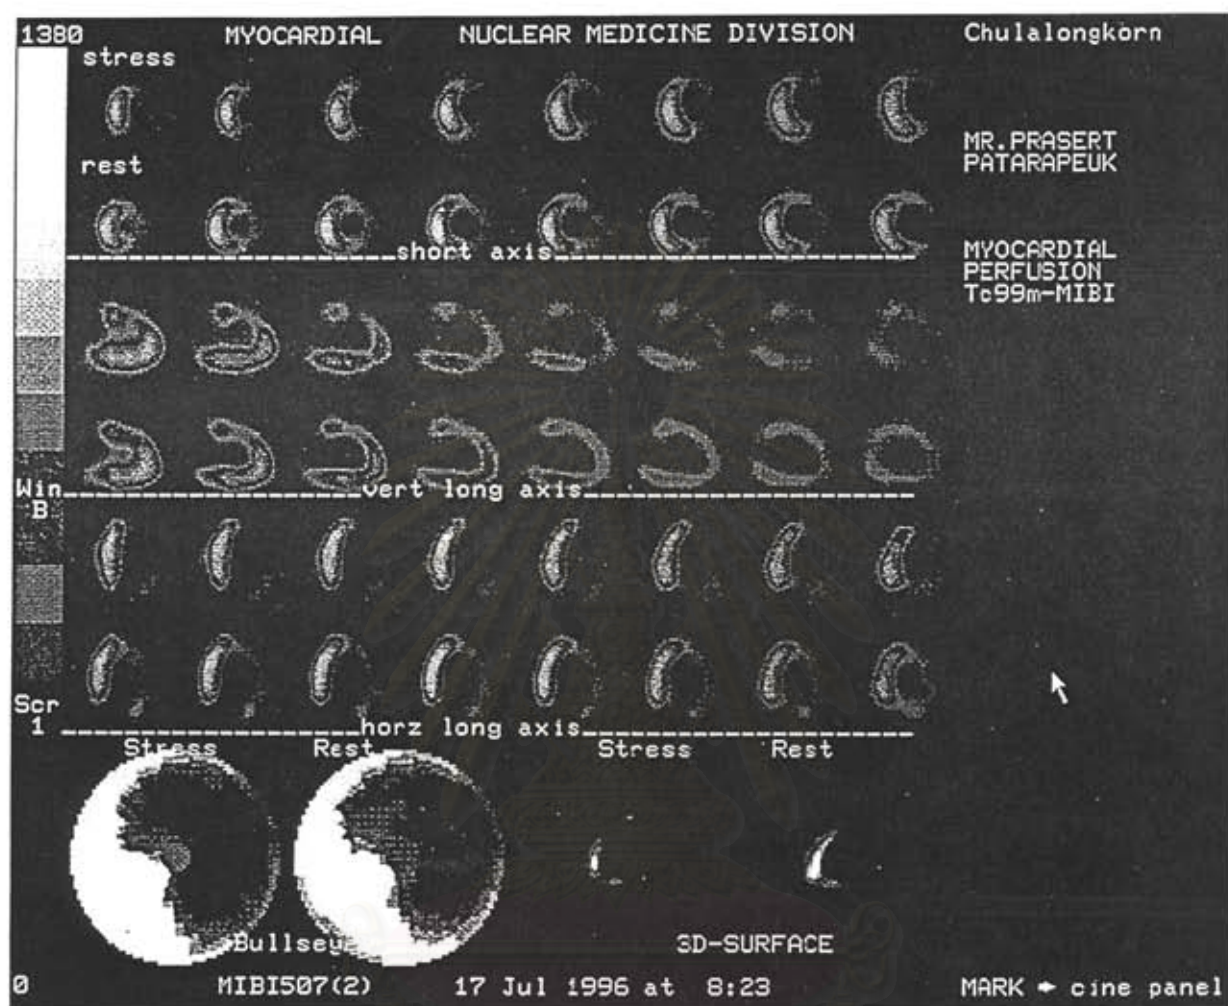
At the 6 months follow-up, Tc-99m Sestamibi SPECT imaging showed worsening of reversible filling defect of the anterior, lateral and apical wall corresponding to angiographic restenosis of LAD
